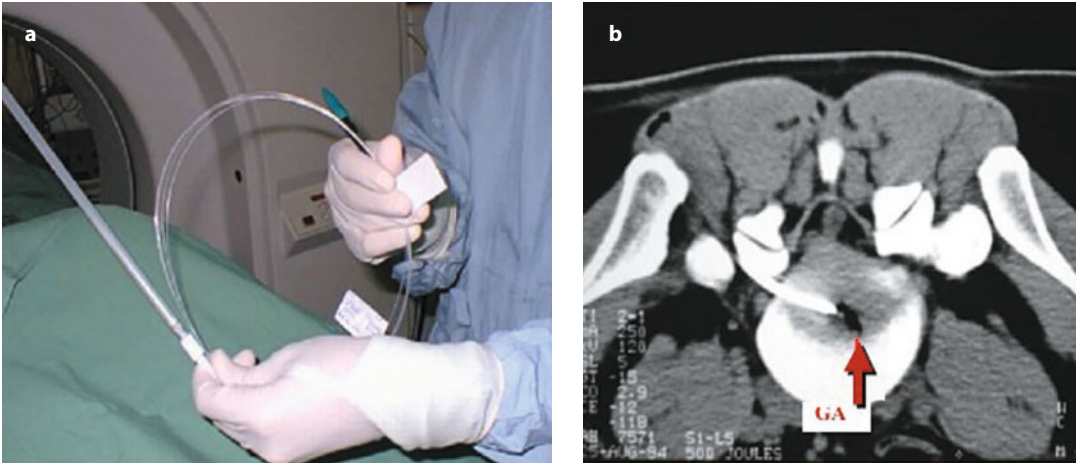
Patient with left posterolateral herniated disk at the L5–S1 level being treated by percutaneous laser disk decompression under CT guidance (a). Post-treatment axial CT in a patient in the prone position using a posterolateral approach (b)
